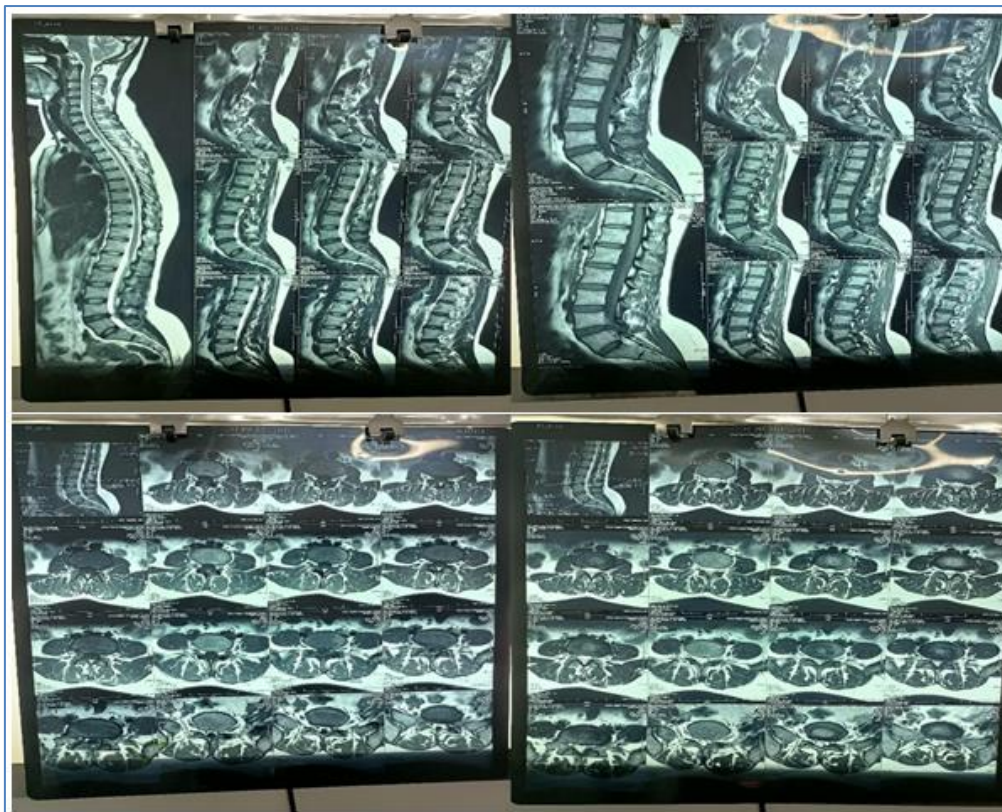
MRI of Lumbo Sacral Spine with screening of WS revealing Disc dehydration at L4/L5 level with reduced disc height. Posterior central and left paracentral disc bulge, facetal hypertrophy causing thecal sac in indentation, mild canal stenosis & left lateral recess of facement.
